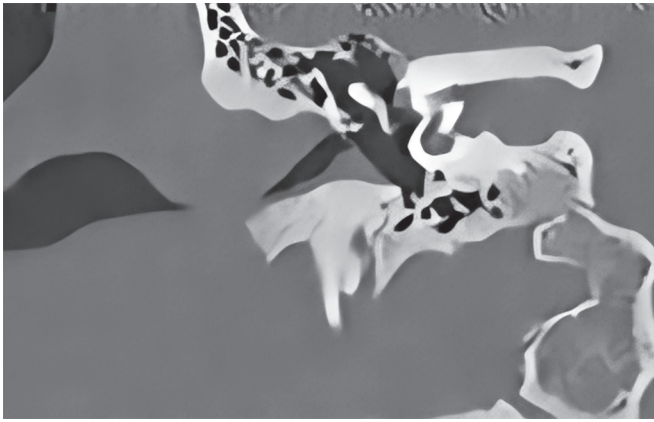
In the coronal view of temporal bone CT scan, soft tissue shadows were observed in the posterosuperior wall of the ear canal
